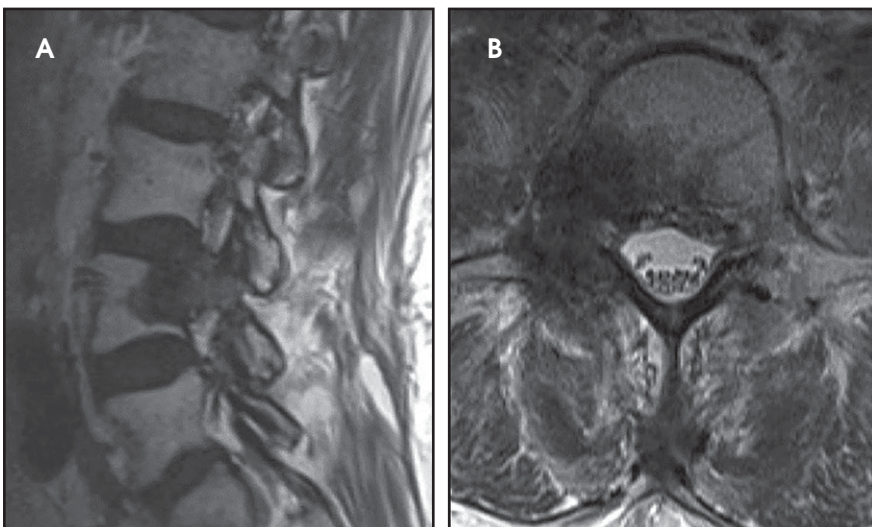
(A) Sagittal and (B) axial T2-weighted MR images of the lumbar spine 6 months following SRS (6/2014). The volume of epidural disease has decreased, and there is no evidence of local progression. However, there is slight posterior wedging of the L4 vertebral body.
